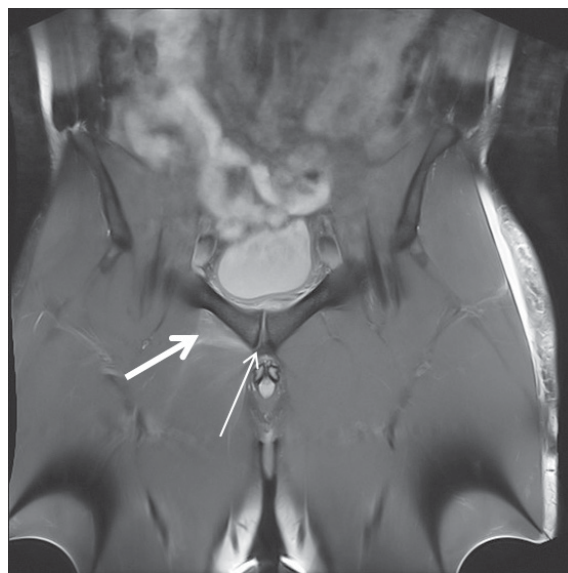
Concomitant injuries. Same patient as in Figure 1 and 3. In proton-density fat-suppression (PDFS) coronal image, a mild hyperintensity of adductor muscles is visible (thick arrow) indicating mild distension without fibre disruption. In addition, note secondary cleft sign (thin arrow) at the lower right edge of the pubic symphysis indicating possible injury of the rectus/adductor aponeurosis. In such case, a dedicated MRI examination might be warranted.
